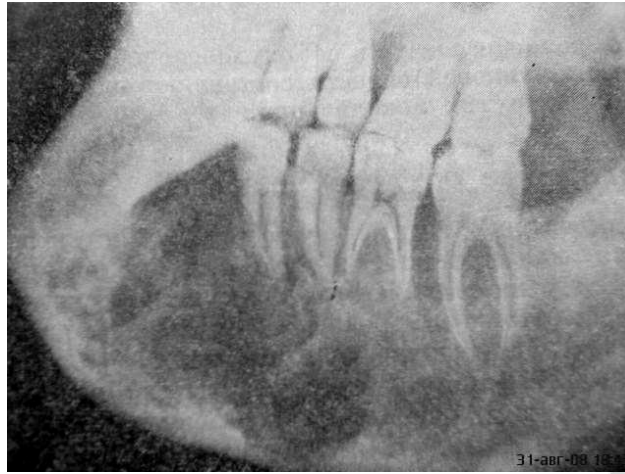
X-ray image of the cellular form of osteoclastoma
